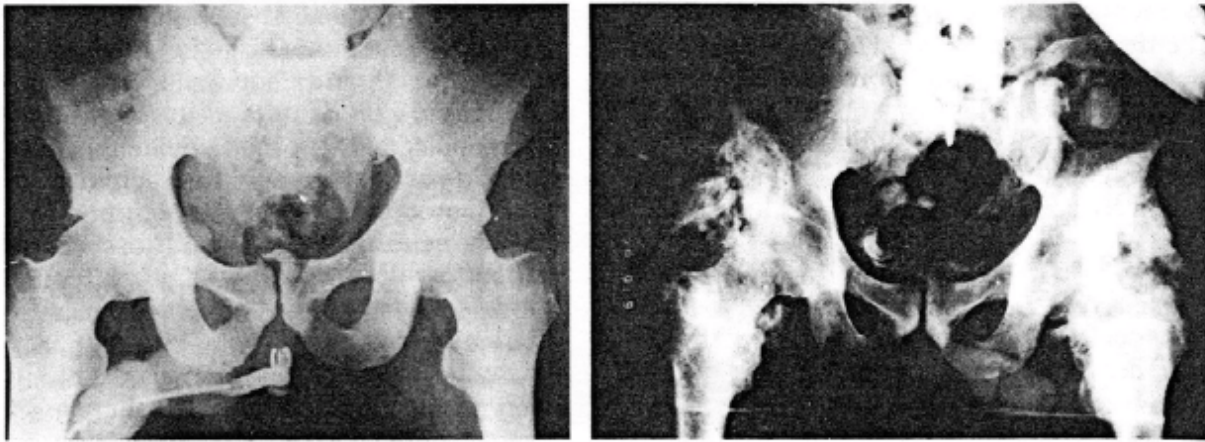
Radiographs of the pelvis of a 30-year-old paraplegic man. The x-ray on the left was taken within a few days after the onset of a spinal cord injury. It shows an indwelling catheter in place, but the bony structures are intact. The radiograph on the right was obtained at the time of admission to a rehabilitation center, 10 months after the injury. The patient had remained in bed during all this time. The radiograph shows abundant soft tissue calcification around the head of both femurs.
